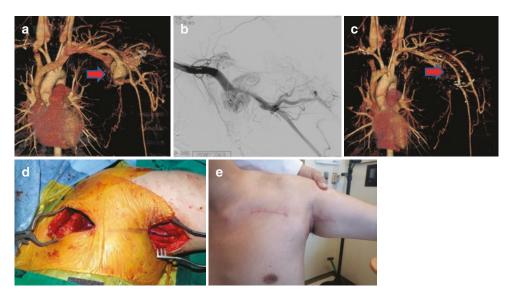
CC: pulsating mass on left sub-clavicular and axillary area. Dx: Arteriovenous malformation. (a) preop CTA: AVM involving left subclavian and axillary artery. (b) preop coil embolization. (c) postop CTA: bypass
